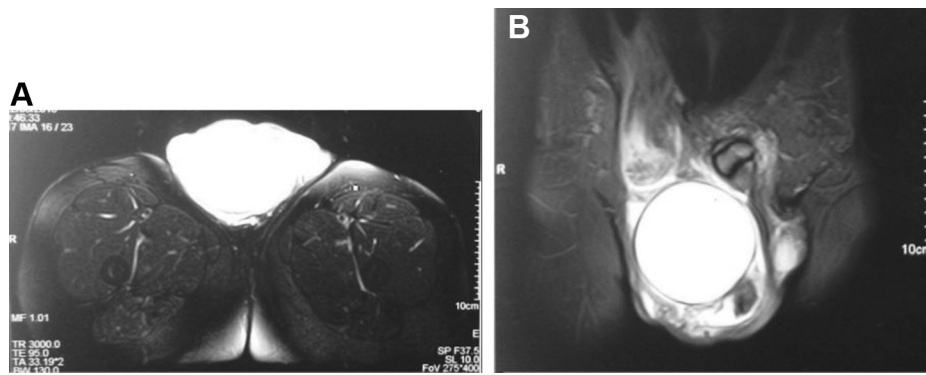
The magnetic resonance imaging examination revealed appearance of intrascrotal fluid collection, with the size of (A) 8.91 × 6.95 cm on axial section and (B) 8.98 × 8.81 cm on coronal section.
